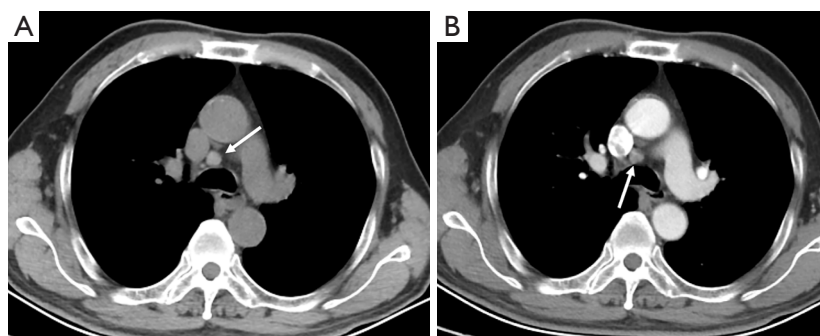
A non-metastatic node in a patient with gastric carcinoma. (A,B) A 70-year-old male patient with gastric carcinoma and pathologically confirmed non-metastatic node. Chest CT detected an enlarged lymph node at 4R group (white arrows). The pathological results of EBUS-TBNA indicated benign lymph node. The size of this lymph node was 10 mm × 10 mm. (A) The plain CT attenuation value was 62 HU. (B) The CECT attenuation value was 65 HU. CT, computed tomography; EBUS-TBNA, endobronchial ultrasound-guided transbronchial needle aspiration; CECT, contrast-enhanced CT; HU, Hounsfield unit.
